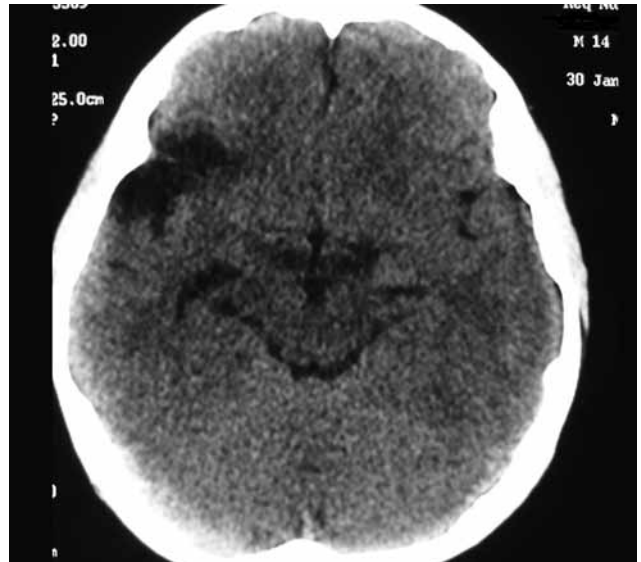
Repeat CT scans revealed an encephalomalacic area on the right temporal lobe.
